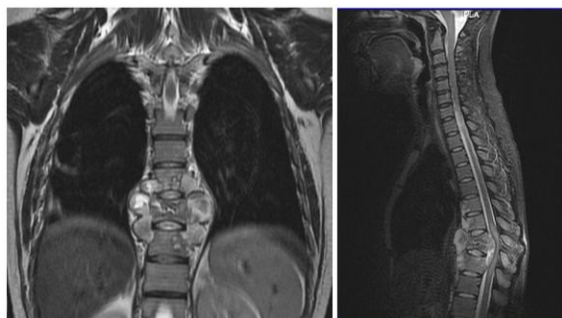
Tuberculous spondylitis Th 6-7-8-9-10, spondylitis phase: MRI of the thoracic spine, coronary and sagittal projection (focal and contact destruction in Th 6-7-8-9-10 bodies with the destruction of Th 8-9 bodies and compression fracture; multi-chamber abscesses with an inhomogeneous signal with end plates destruction in the epidural and paravertebral regions)
